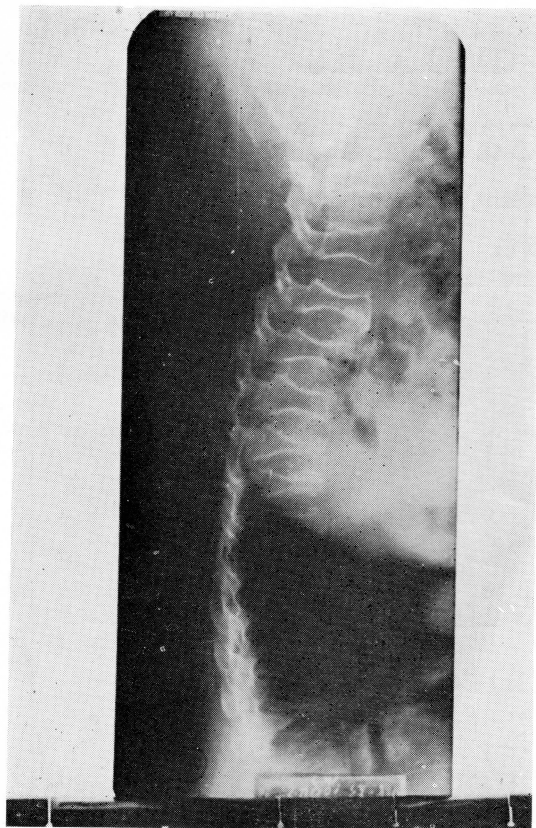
X-ray of spine showing osteoporosis and collapse of vertebrae.
